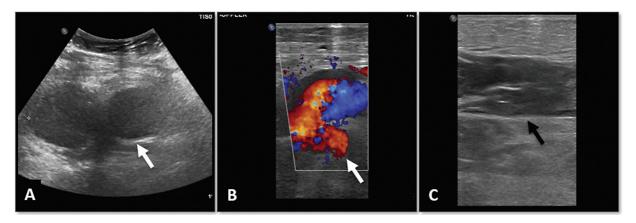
(A,B) Duplex ultrasonography (USG) shows a hypoechoic collection in the thigh that was continuous with the superficial femoral artery and shows color filling (*white arrow*), suggesting a pseudoaneurysm. (C) Hypoechoic collection in the muscular plane (*black arrow*) suggesting possible hematoma.
